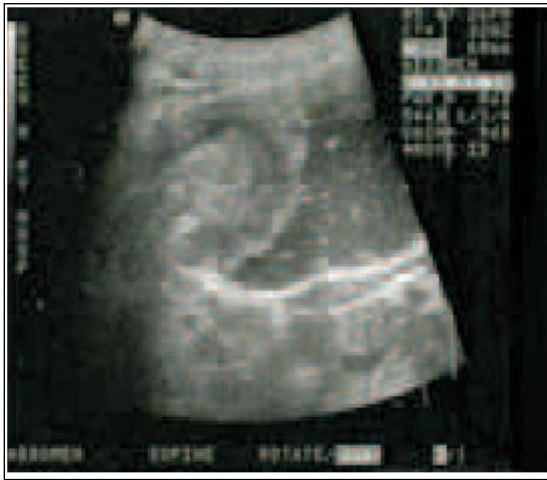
Ultrasound demonstration of the movement of mass with saline infusion.
